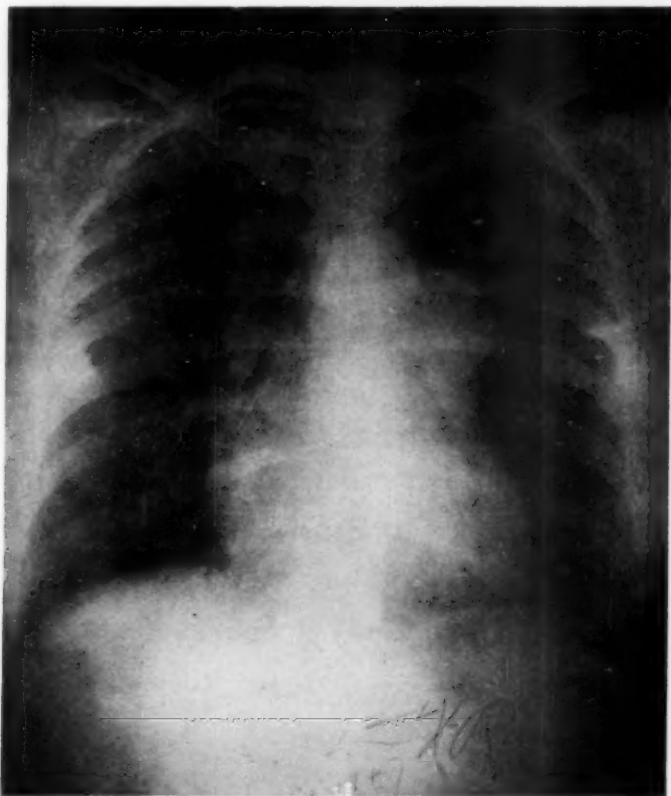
Conventional roentgenogram made four years prior to final hospital admission. The left hilar density was interpreted as an enlarged pulmonary artery associated with either rheumatic or congenital heart disease.
